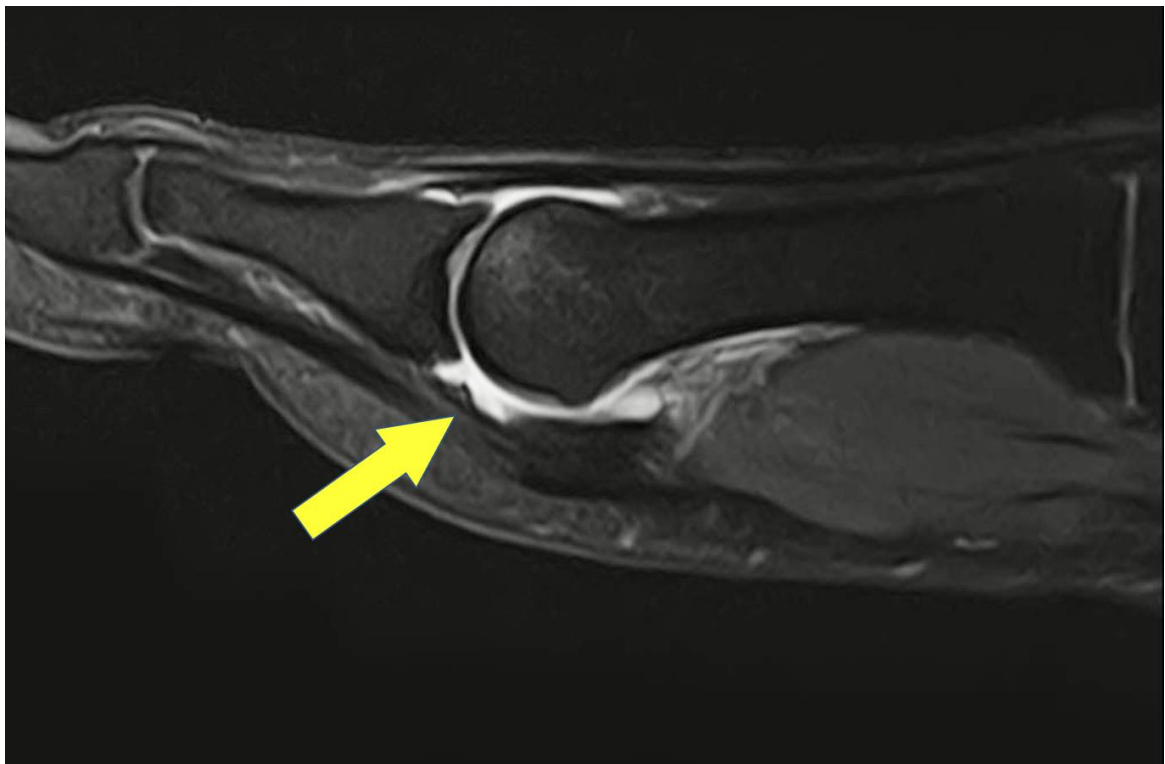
MRI arthrography of 1st MTP jt
